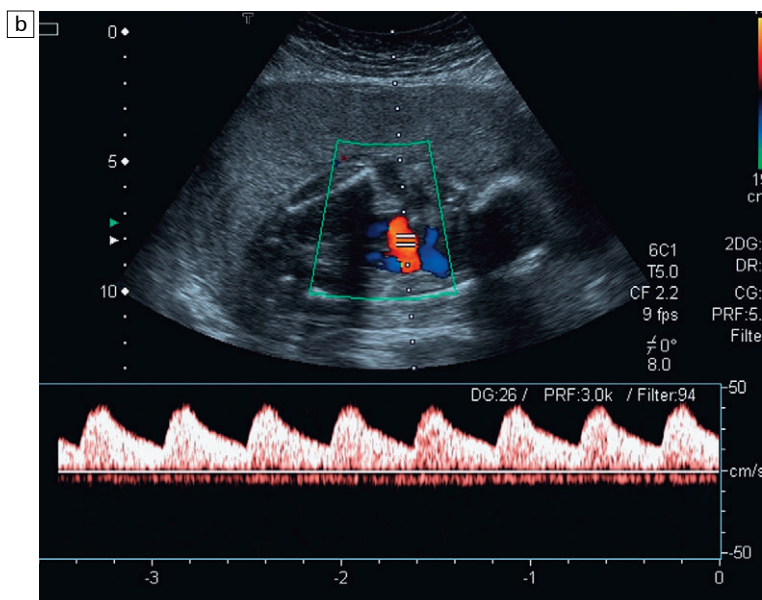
(a) Relative oligohydramnios. Colour flow Doppler demonstrating umbilical arteries in the pelvis on either side of an empty bladder. (b) Relative oligohydramnios sampling from the umbilical artery within the pelvis demonstrates normal umbilical artery flow patterns.
